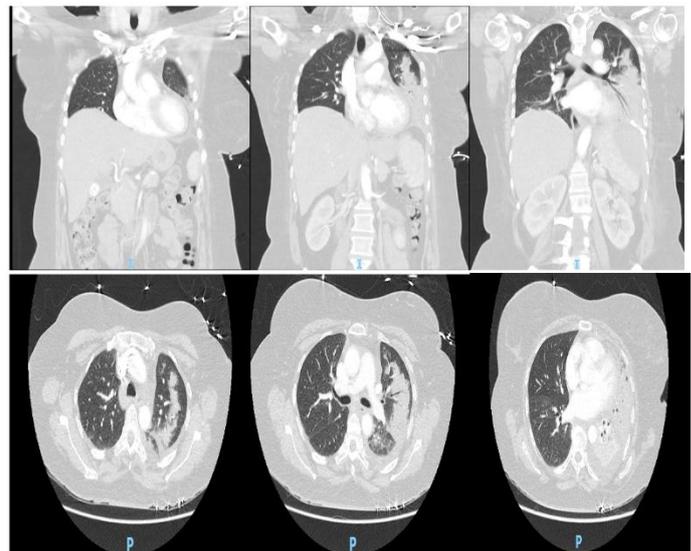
CT Chest showing consolidation, left sided effusion and atelectasis
